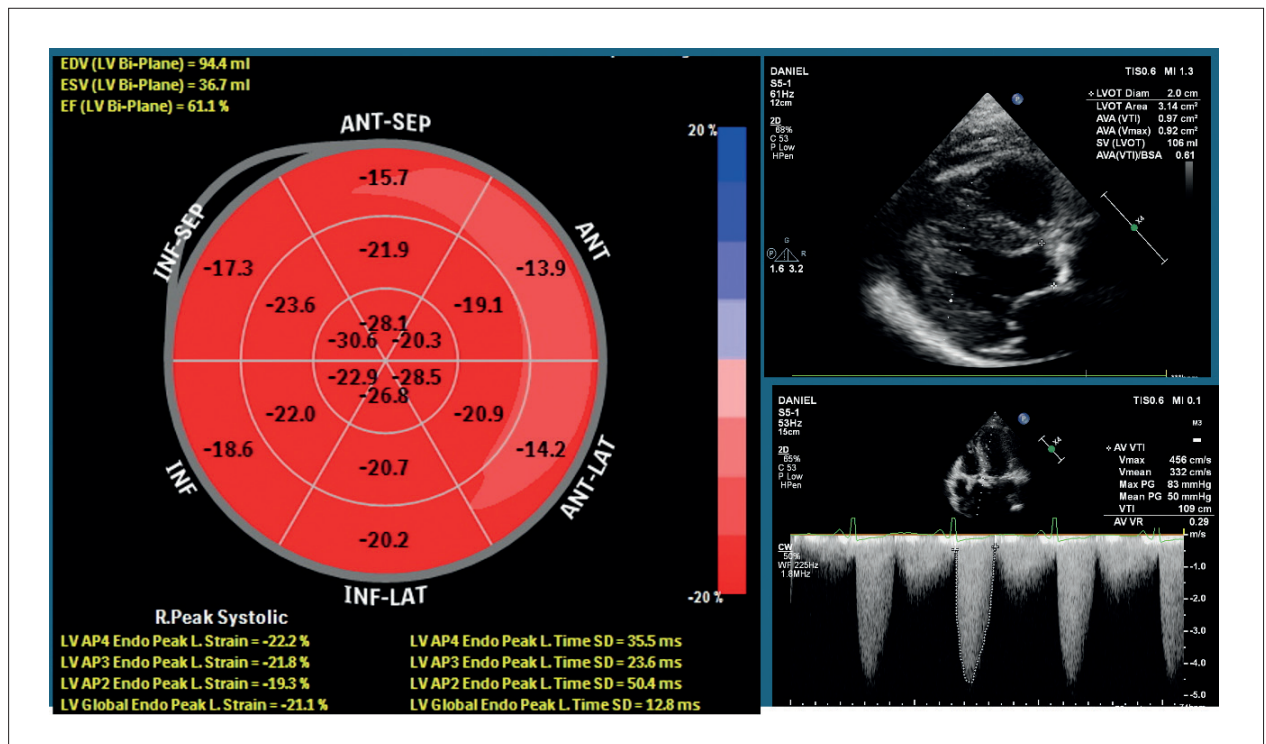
Two-dimensional transthoracic echocardiography with color Doppler demonstrating severe aortic stenosis. Top right: Parasternal longitudinal view showing left ventricular hypertrophy and calcified aortic valve. Bottom right: Transvalvular velocity > 4.5 m/s and mean gradient = 50 mmHg. Left: Bull's eye map showing normal global longitudinal strain = 21.1%.
